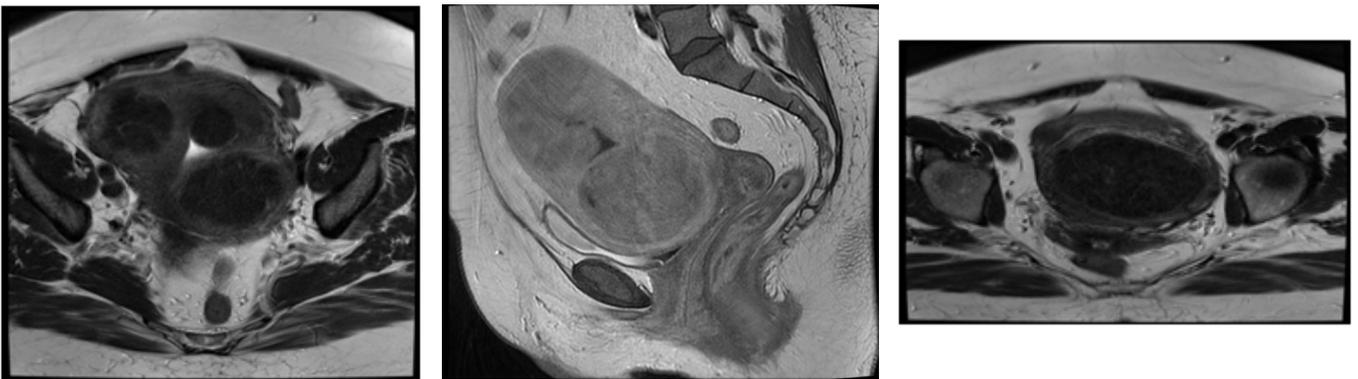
5 & 6: MR images show multiple large fibroids in uterus.
